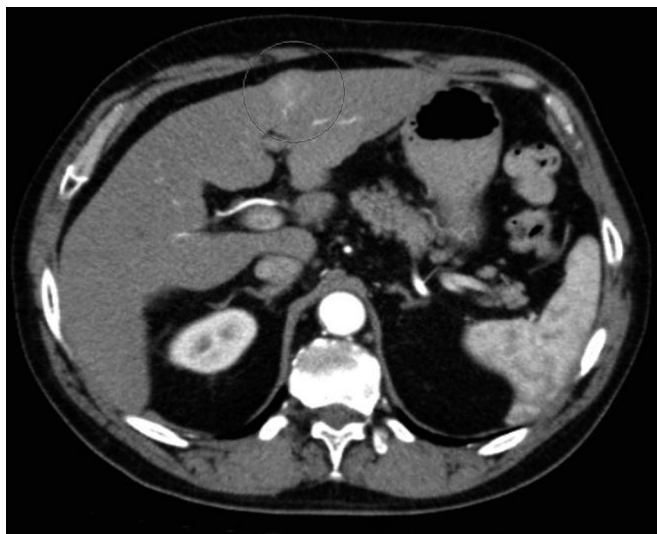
CT scan (B) shows a 3.4-cm mass consistent with HCC in segment III. HCC: hepatocellular carcinoma.
